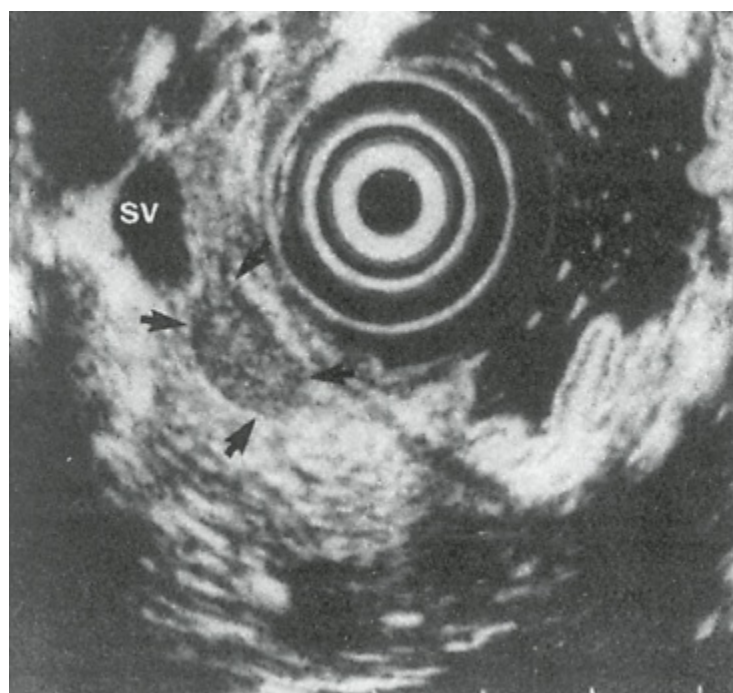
Endoscopic ultrasonographic image from a patient with an insulinoma (*arrows*) in the body of the pancreas. SV, splenic vein. (From Rosch T, Lightdale CJ, Botet JF, et al. Localization of pancreatic endocrine tumors by endoscopic ultrasonography. *N Engl J Med* 1992;326:1721-1726, with permission.)
